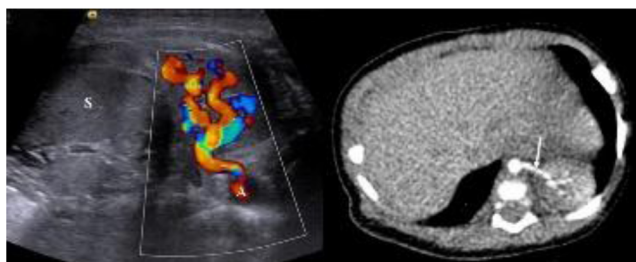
Color Doppler ultrasound (left image) and axial contrast-enhanced CT in the arterial phase (right image) showed a systemic arterial supply (arrow) from the descending aorta (A) of the left lung base sequestration. S - spleen.
